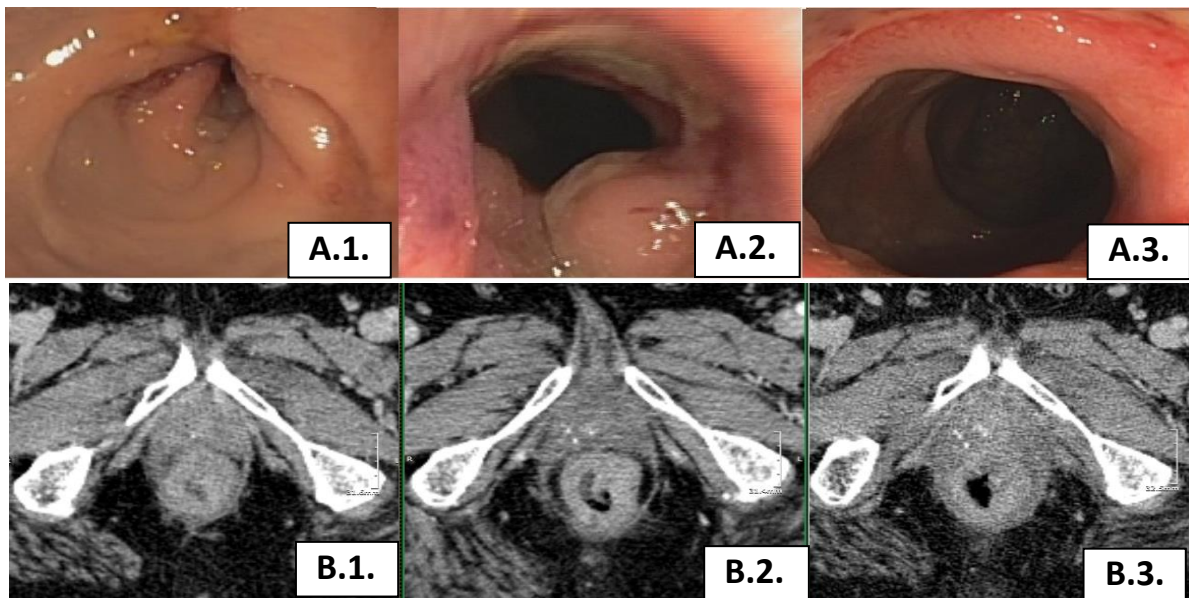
Colonoscopy (A.) and CT scan (B.) images at diagnosis (1.), relapse (2.) and at latest posttreatment follow-up (3.)
